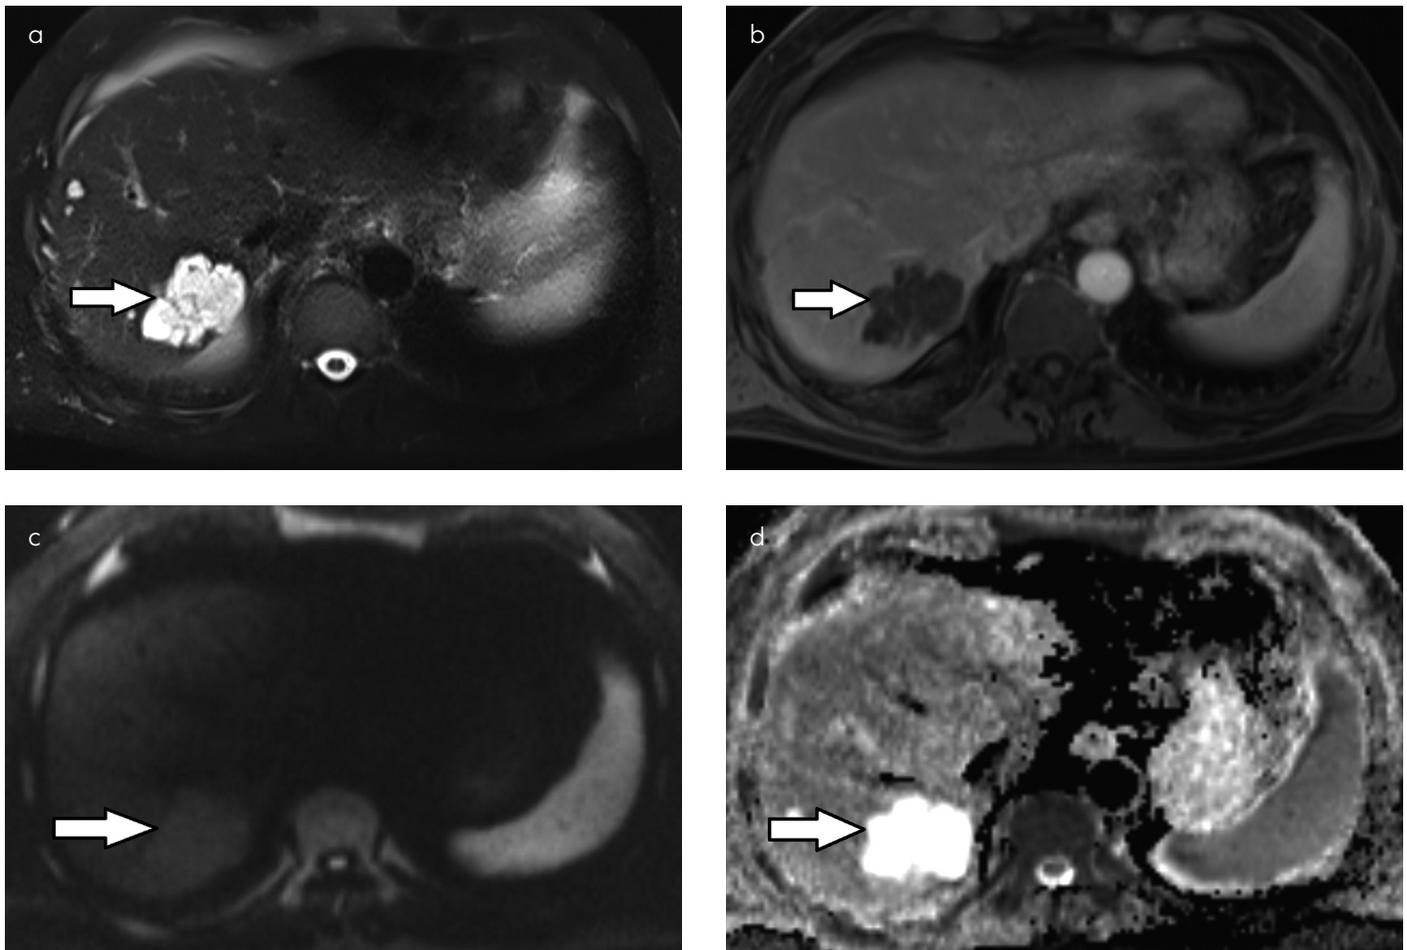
a-d. A necrotic metastasis. The lesion has septa on the T2-weighted image (a) and slight contrast enhancement on these septas on venous phase (b). It is slightly hyperintense on b800 (c) and obviously hyperintense on ADC map (d)
